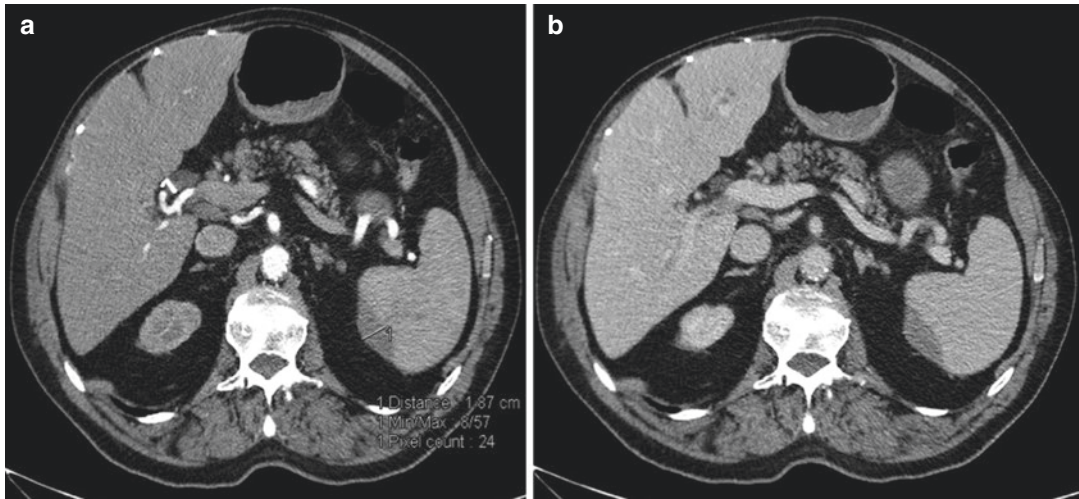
Grade 2: these CT axial pictures show a subcapsular hematoma, smaller than 3 cm, studied in both arterial (a) and venous phase, (b). The arterial phase is more sensitive for the evaluation of vascular injury
